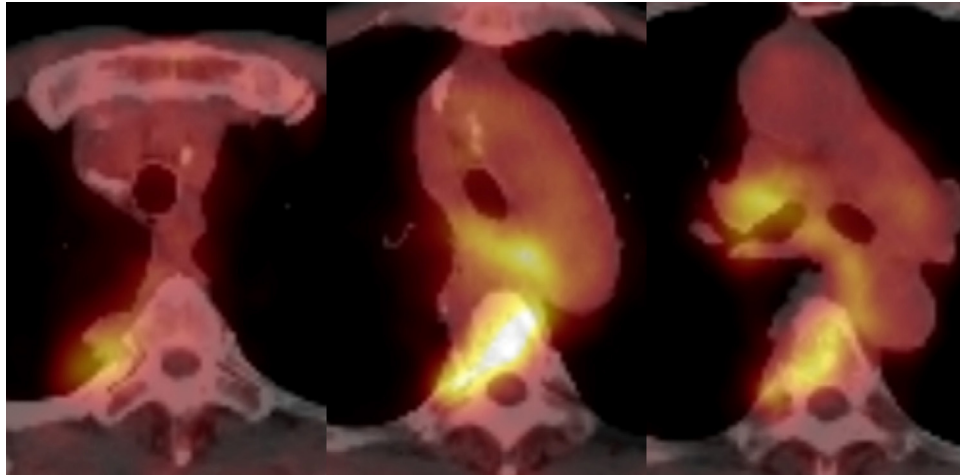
^{18}F -FDG PET-CT shows avid uptake in the peripheral rim of the mass. Hypermetabolism of the adjacent thoracic vertebral body was also seen (maxSUV: 4.8).
